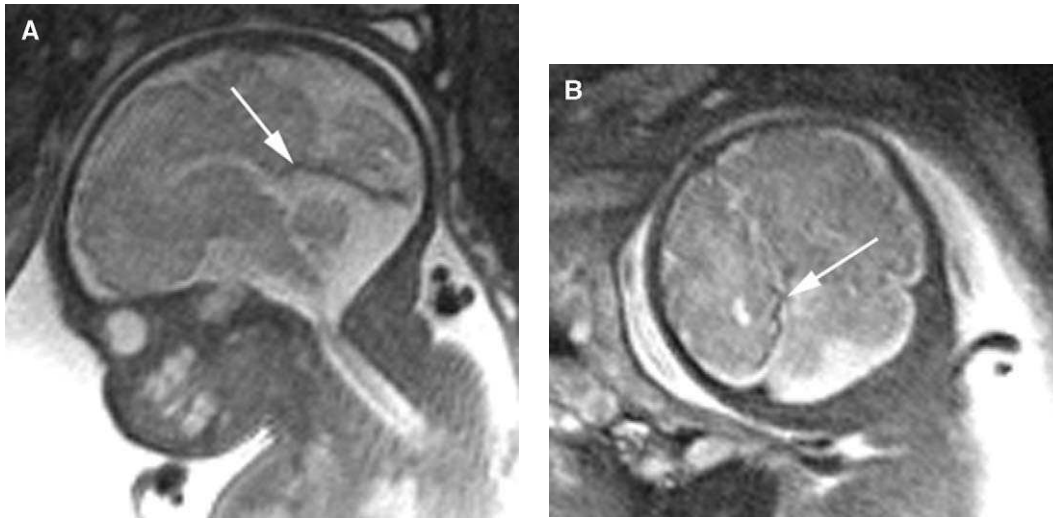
Fetus at 35 weeks' gestation referred for enlarged cisterna magna. Sonogram was normal (not shown). Sagittal (*A*) and coronal (*B*) MR images show incidental finding of enlarged subtemporal vein (*arrow*). This is an example of the risk of MR showing an unrelated finding that could increase parental anxiety. The patients were counseled that this was a vascular anomaly that would have gone unrecognized if the MR examination had not been performed. Postnatal outcome was normal at 2 years of age.
